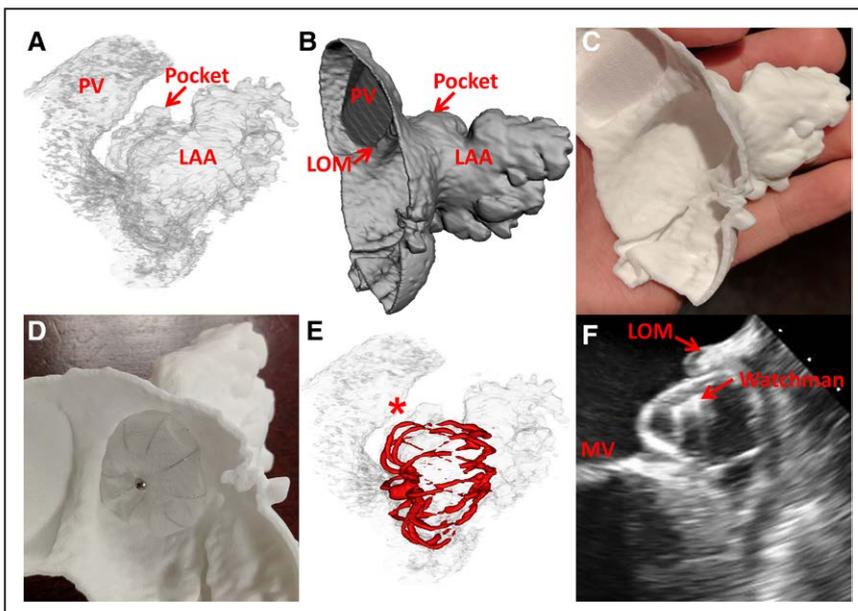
The left atrial appendage (LAA) was segmented (A) using the Intuition software with additional processing and smoothing performed using Meshmixer and Blender freewares (B). The stereolithography file was submitted for printing by Sculpteo (C), an online consumer printing service, and multiple Watchman device sizes were tested in the printed model for the best fit (D). Postprocedural multidetector computer tomography and transesophageal echocardiogram images confirm position of the device as predicted by in vitro testing (E, F). LOM indicates ligament of marshal; MV, mitral valve; and PV, pulmonary vein.
